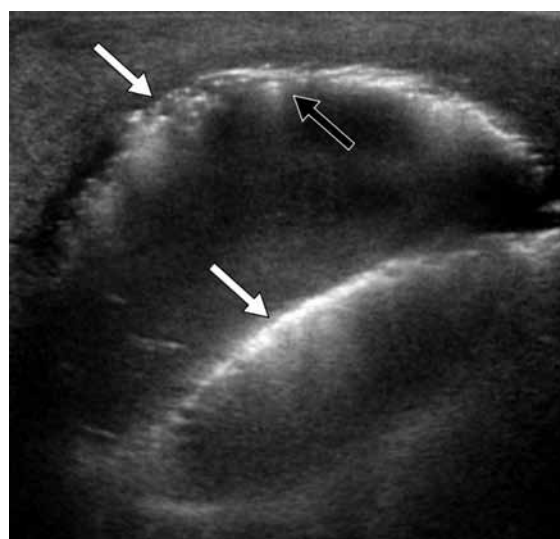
Ultrasound image of the left hemiscrotum showing a fluid collection with hyperechoic interfaces (white arrows) and ring-down artefact (black arrow) suggestive of the presence of gas. Underlying structures including the testis and epididymis were obscured
